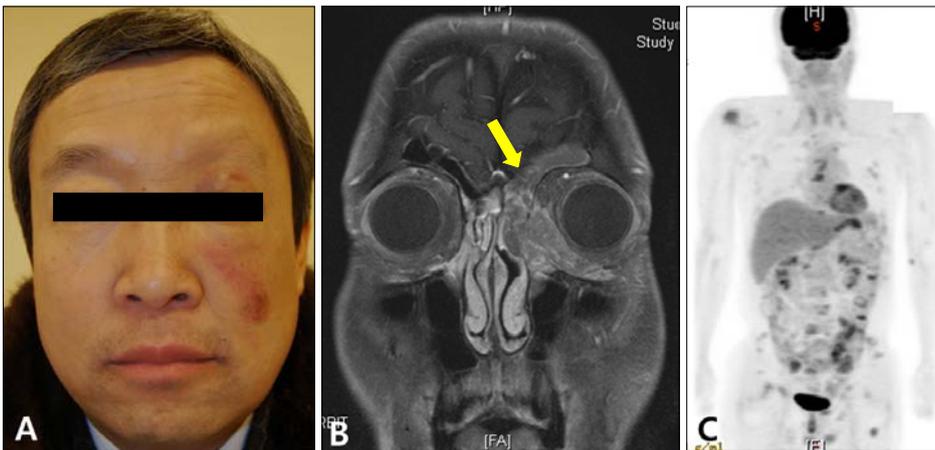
Photograph, magnetic resonance (MRI) and positron emission tomography-computed tomography (PET-CT) scan of the patient. (A) Solitary coin sized erythematous to purple plaque on Lt. cheek. (B) MRI scan demonstrating local recurrence on the left medial orbital wall. (C) PET-CT scan revealed newly developed numerous osteolytic lesions.
